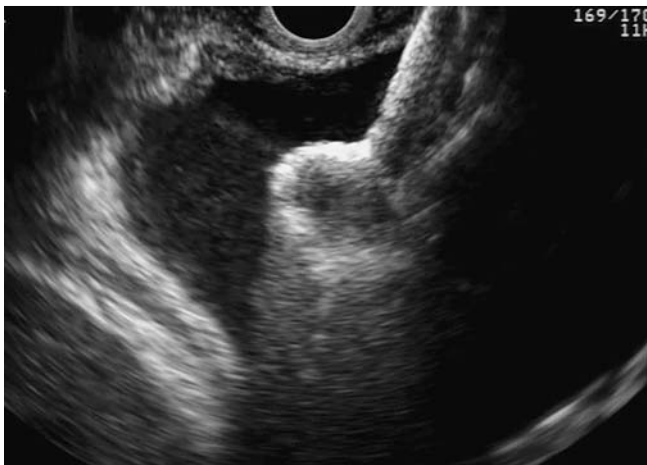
View during endoscopic ultrasound (EUS)-guided placement of a lumen-apposing metal AXIOS stent across the cystoesophagostomy.
